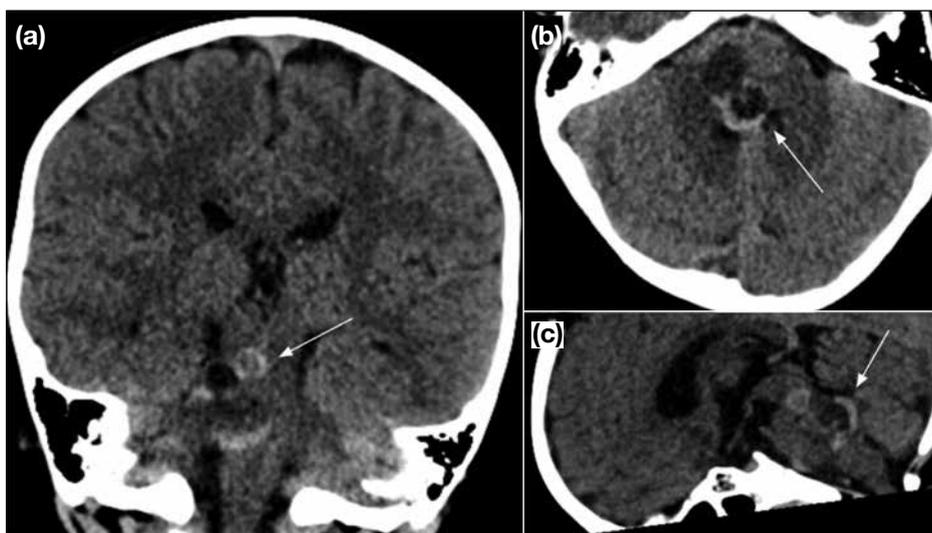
Non-contrast enhanced computed tomography brain with (a) coronal view, (b) axial view and (c) sagittal view showing a multilobulated lesion of predominantly cystic density with a partial hyperdense rim centred at the pontine region causing narrowing of fourth ventricle (arrows).
